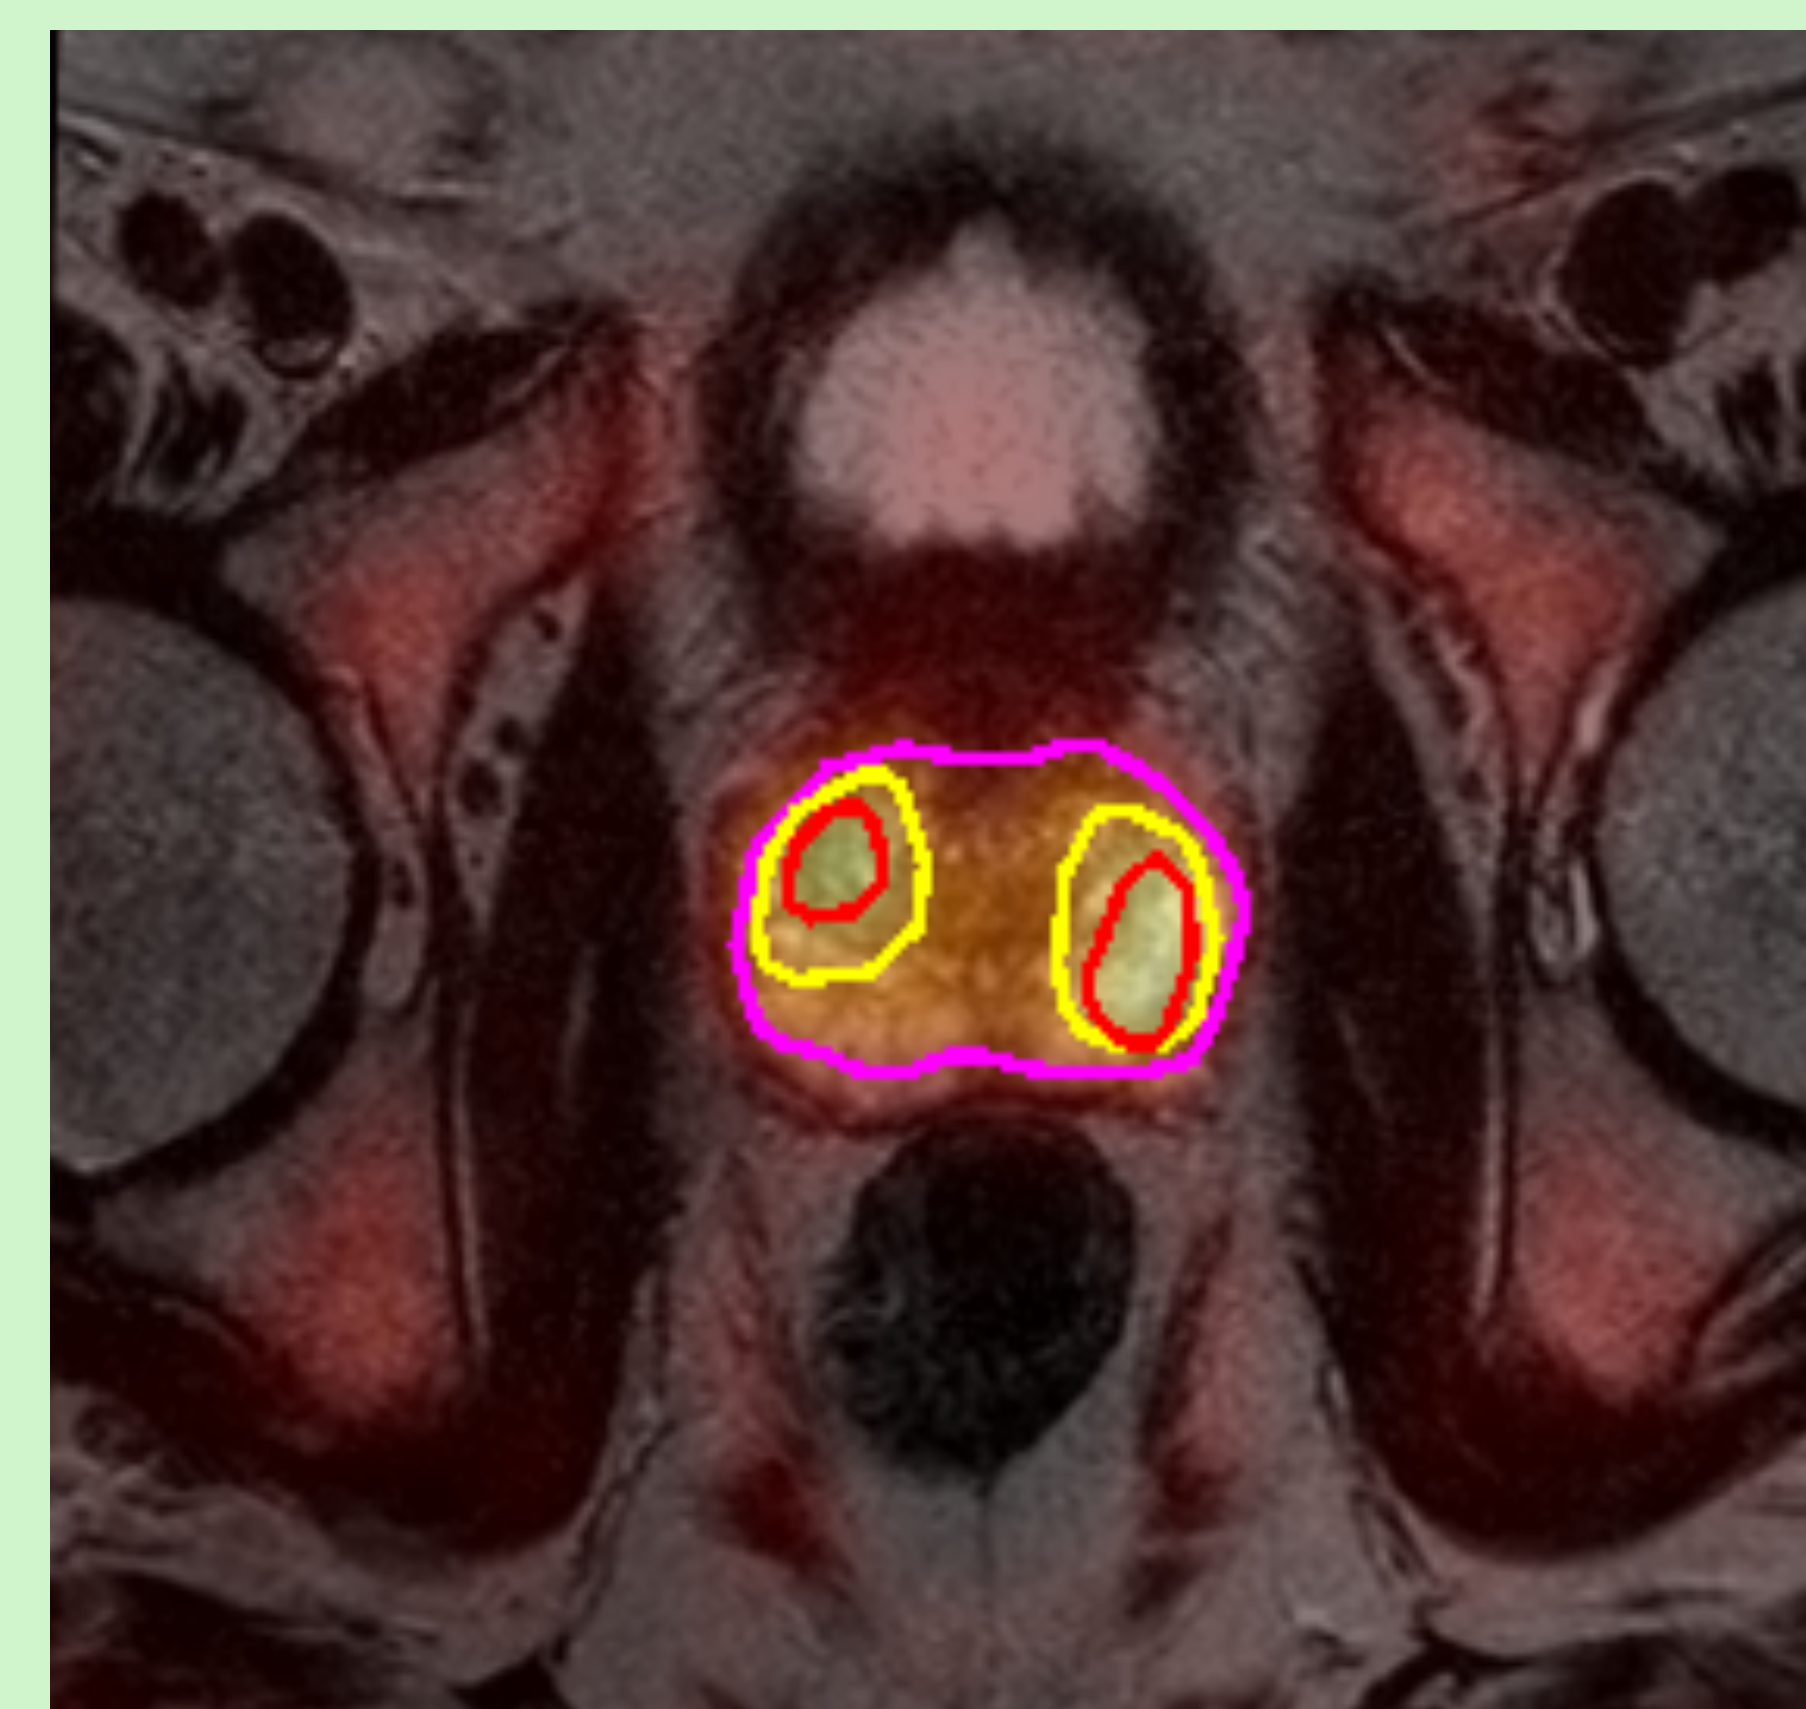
The PET-90 derived contours for c1, c2 and c3 shown on rigid co-registered MRI.
